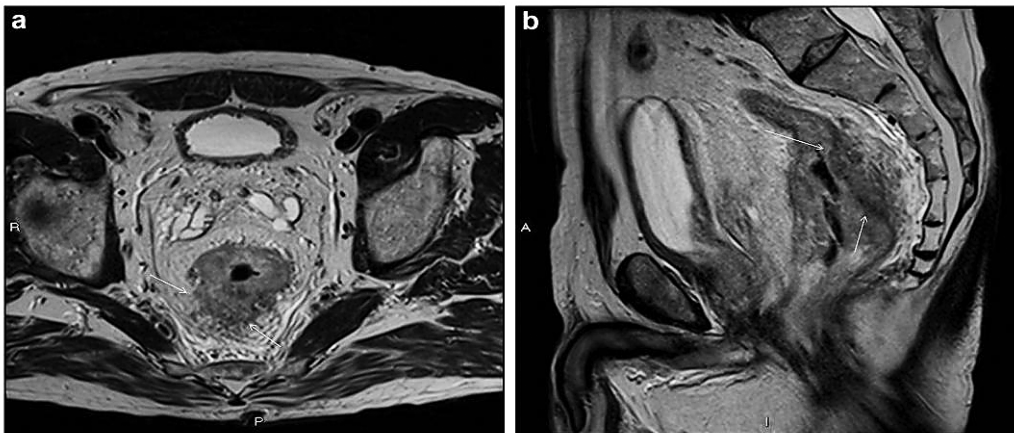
Axial and sagittal MRI scan of advanced rectal cancer (arrows) (with patient's permission).
